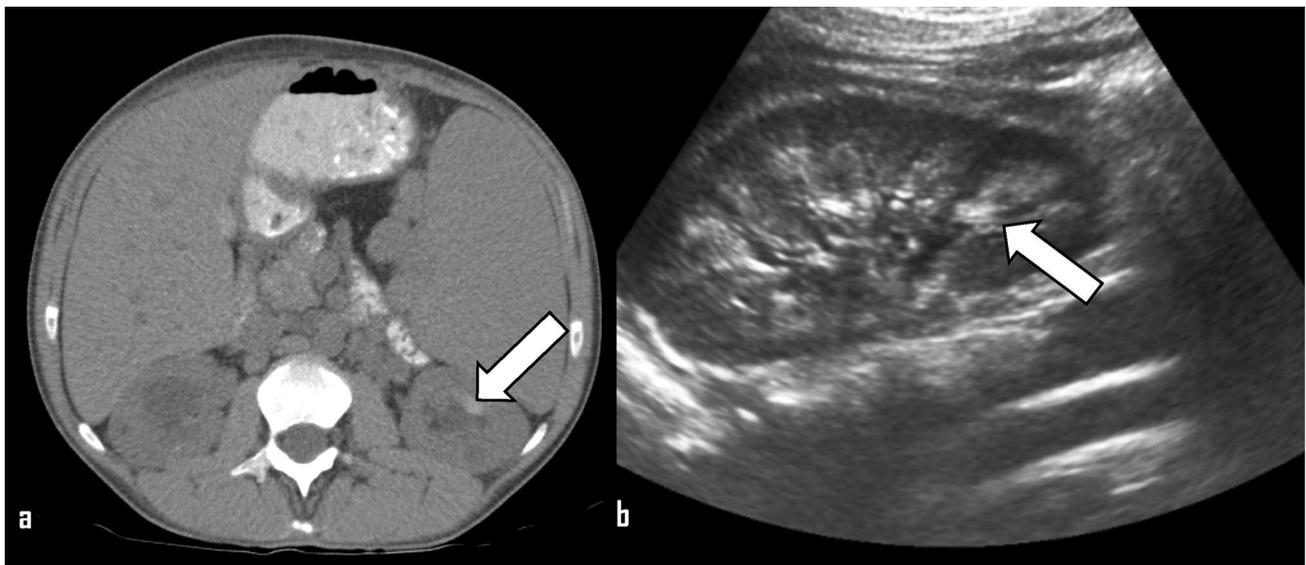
Axial unenhanced CT (a) and US (b) of a 19-year-old female with non-obstructing renal calculi
